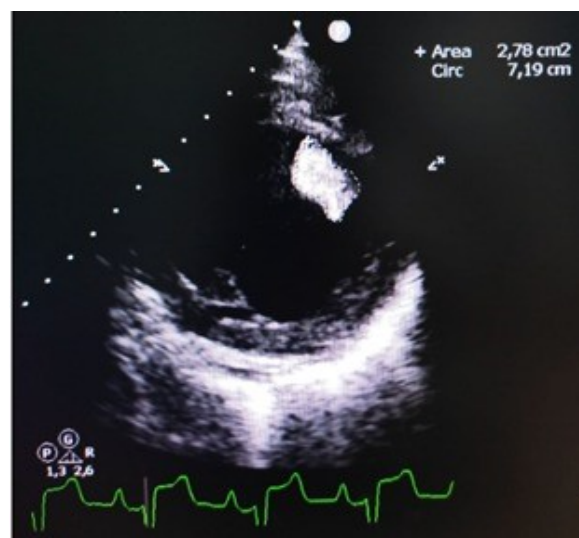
Echocardiography: Parasternal Short Axis View of LV Thrombus
